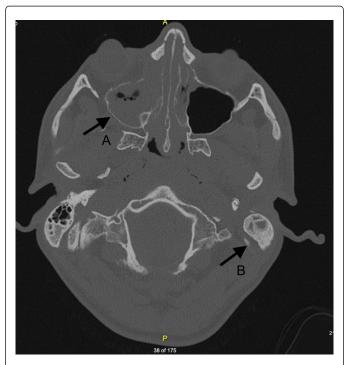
Petrous CT scan pre-mastoidectomy showing with arrow A showing opacification of the right maxillary sinus and asymmetric opacification of the right nasal cavity. Arrow B shows left-sided mastoiditis.
